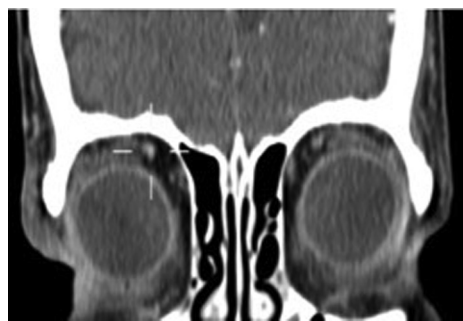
Coronal computed tomography found superolateral diffuse infiltration.
